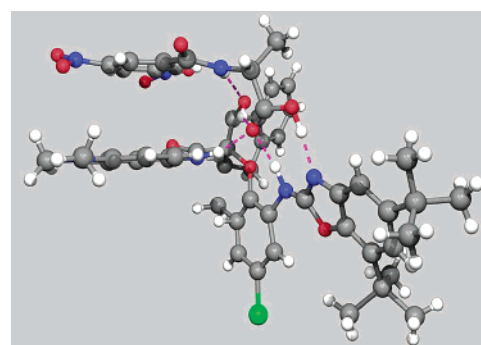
X-ray structure of the (5a*S*,6*R*,11a*R*,*S*) associate between receptor 2 and dinitrobenzoylalanine.
